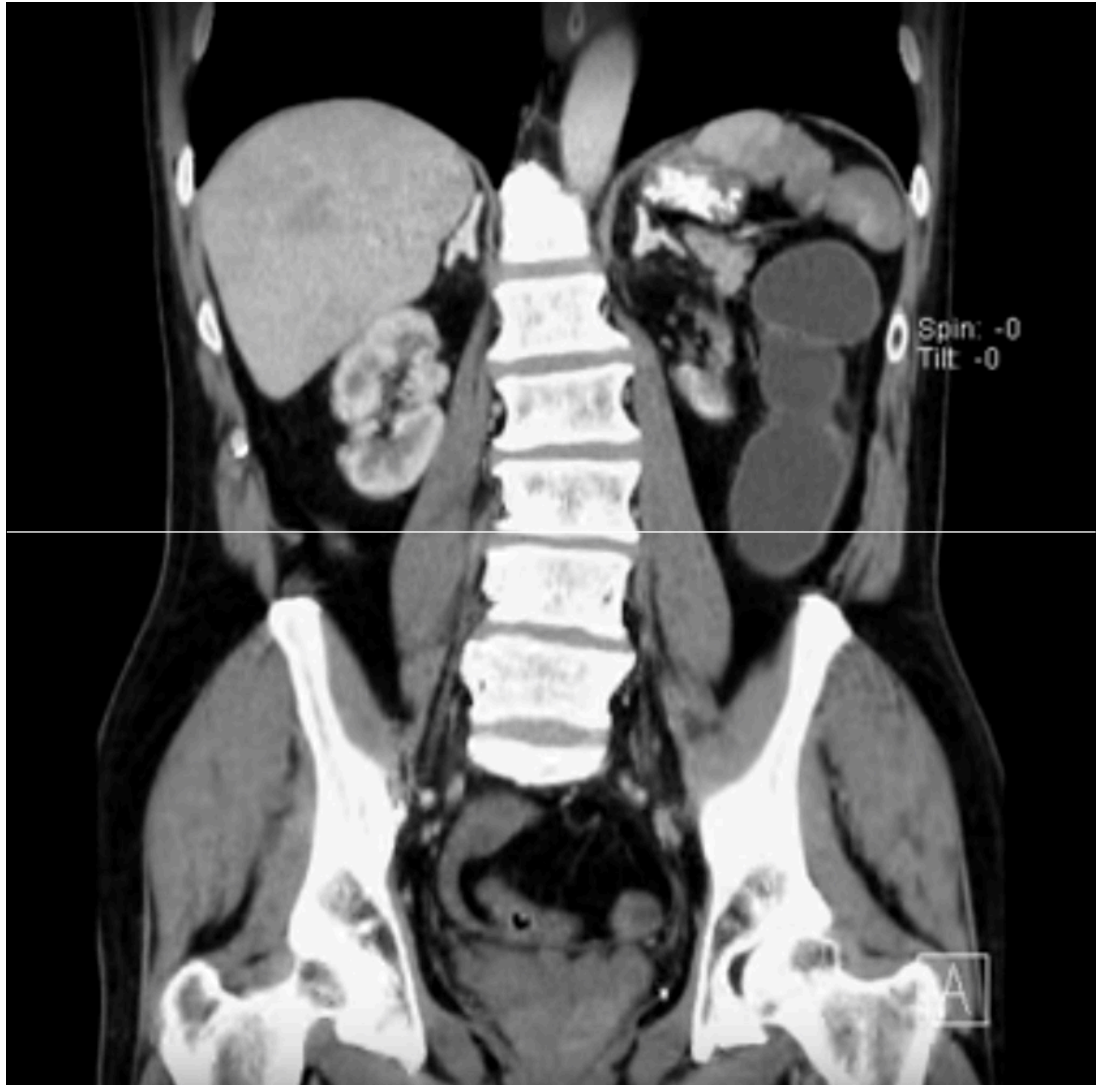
Coronal section of an abdominal computed tomography scan, with a white line representing the the most inferior aspect of the third lumbar vertebral body, without including the intervertebral disc. This method is used to identify the corresponding transverse plane to view, in order to measure transverse cross-sectional area.
